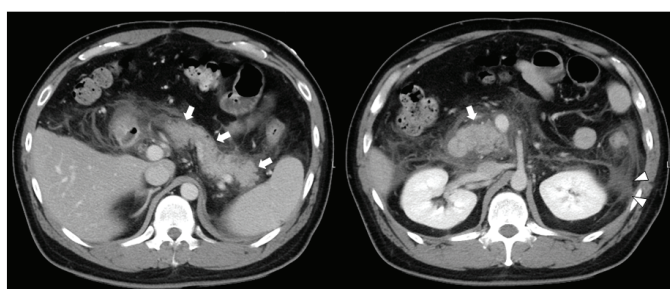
CT imaging of abdomen (Case 3)
